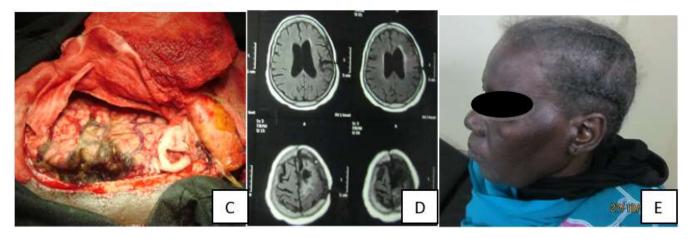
Image (C) is an operative image after total resection of the tumor, Image (D) is post-operative MRI showing no evidence of a residual tumor, Image (E) is the patient after full recovery one year post-operative.
